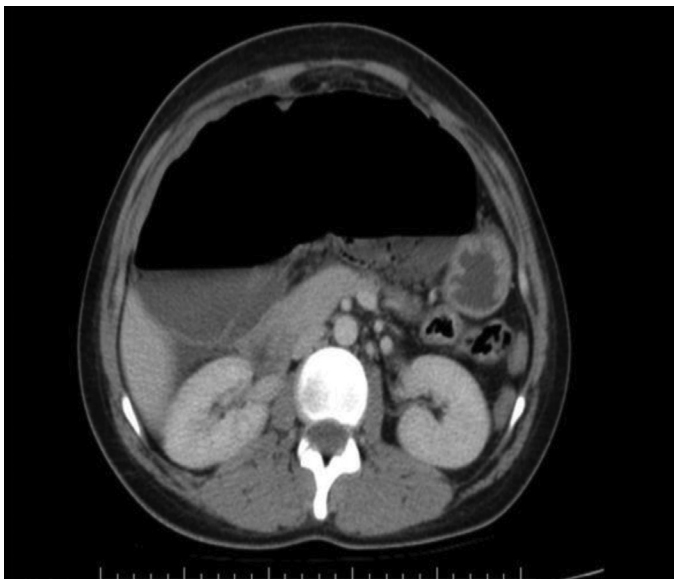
Computed tomography image showing excessive dilatation and air fluid levels in the colon segment
